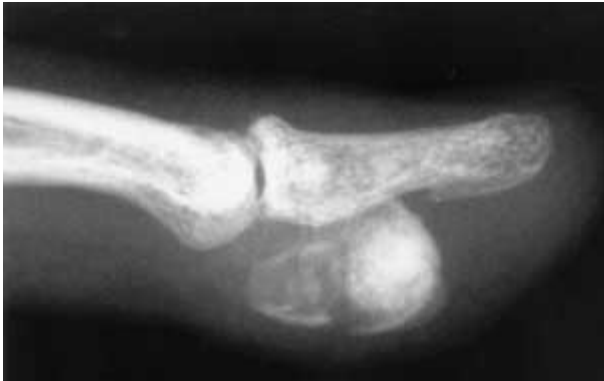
Lateral radiograph of the right index finger showing a large relatively well localized osteoblastic lesion in relation to the volar aspect of the distal phalanx.
